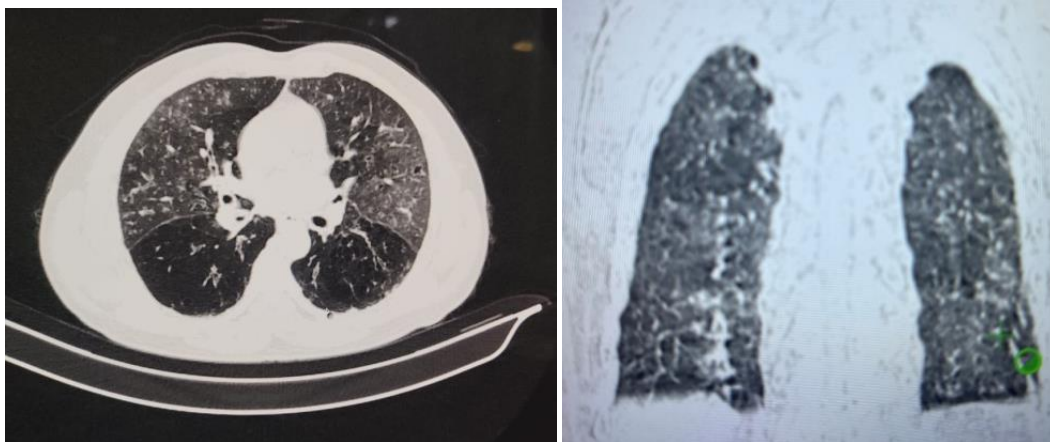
CT showing ground glass opacities both UL
